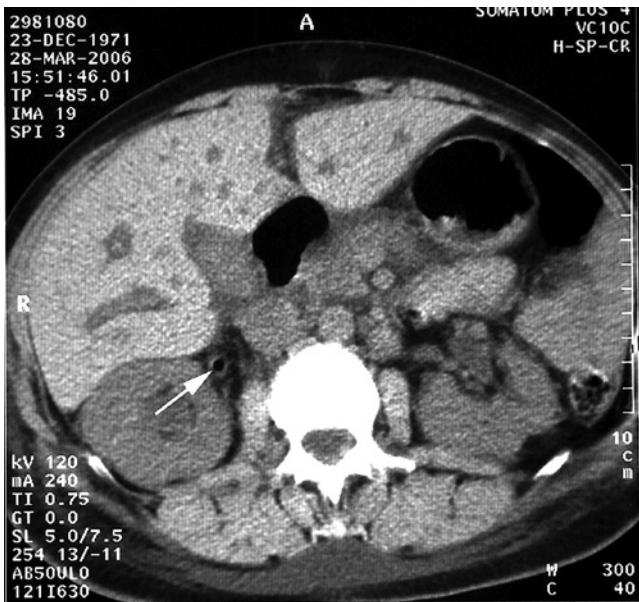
Emphysematous pyelonephritis: computed tomography scan demonstrating gas in the right ureter (arrow) and moderate hydronephrosis in a 34-year-old woman with type 1 diabetes. The responsible organism was *Escherichia coli*. She responded to antibiotics and drainage by nephrostomy, followed by ureteroscopy during which obstructing necrotic slough was removed. Source: Reproduced by permission from Clark et al. (2009) [150]. Copyright © 2009 SAGE Publications.
